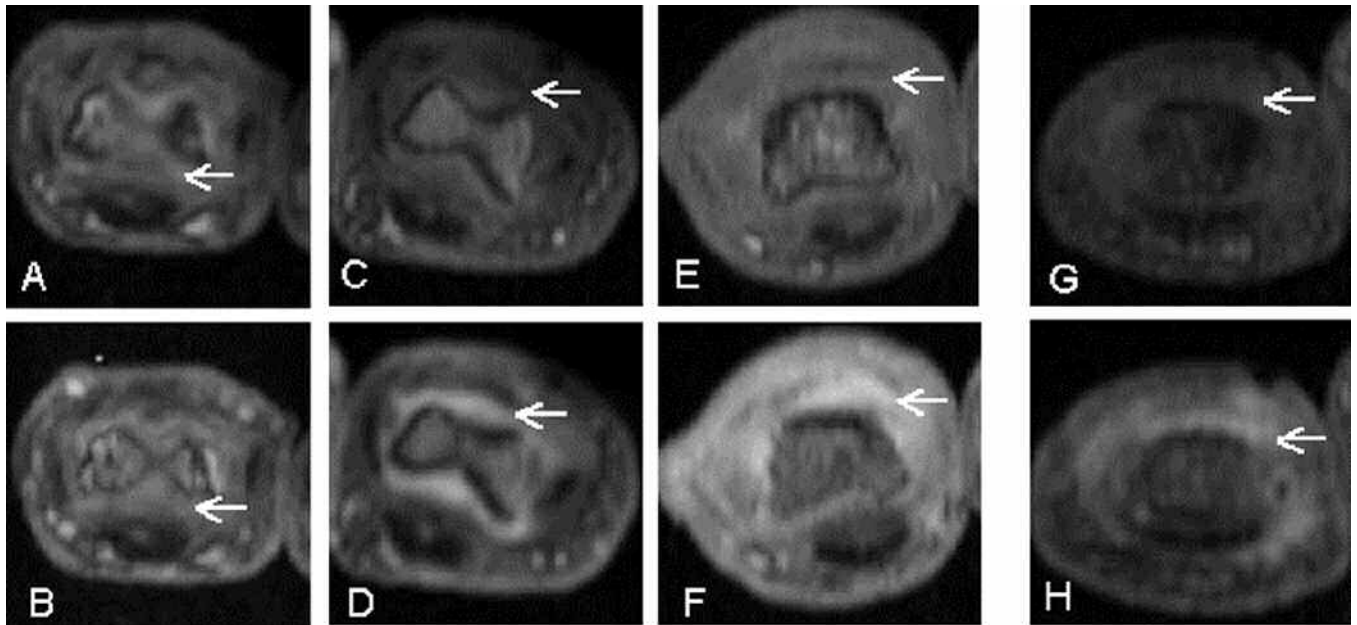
Synovitis in PIP joints (a-b: grade 1; c-d: grade 2; e-f: grade 3) and DIP joints (g-h). Images are in the axial plane (upper row: pre-contrast T1-weighted; lower row: post-contrast T1-weighted).
